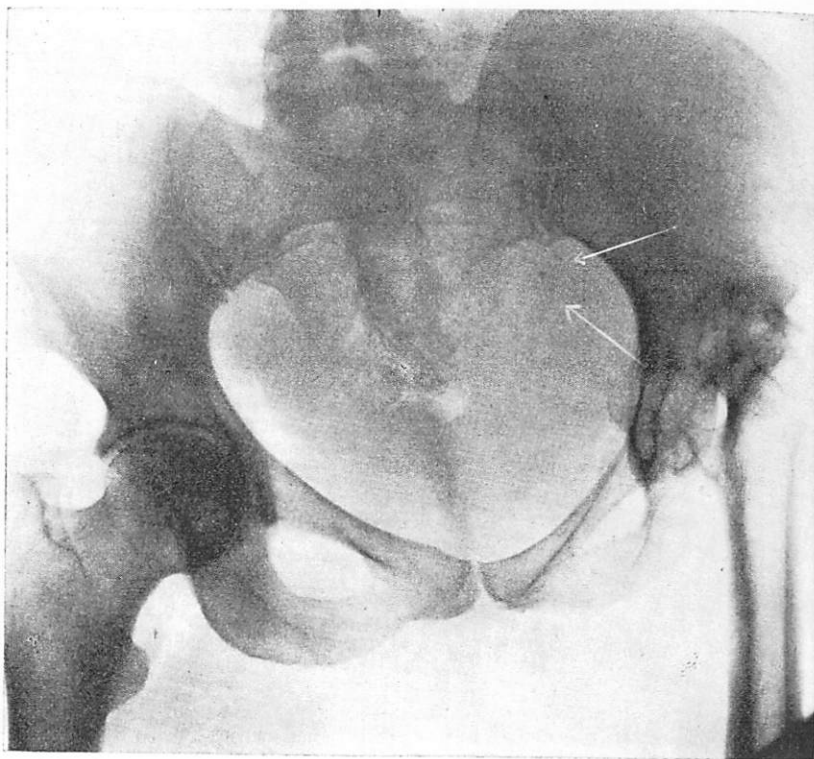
Mrs. F., No. 235. X-ray taken to ascertain type of deformity of pelvis. Obliquity due to ankylosis of left hip and adduction of thigh. Left oblique less than right oblique. Also shows early pregnancy of about fifteen weeks, which can be distinctly seen on the original x-ray plate at points indicated by arrows.
